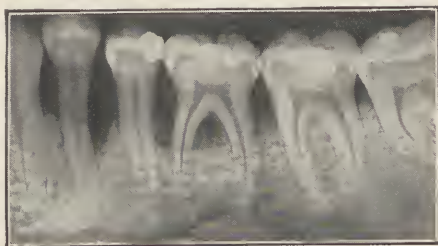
Reproduction of radiograph showing extensive destruction of the bone and alveolar process about lower bicuspid and molar teeth in a case of chronic suppurative pericementitis.—G. V. Black.
